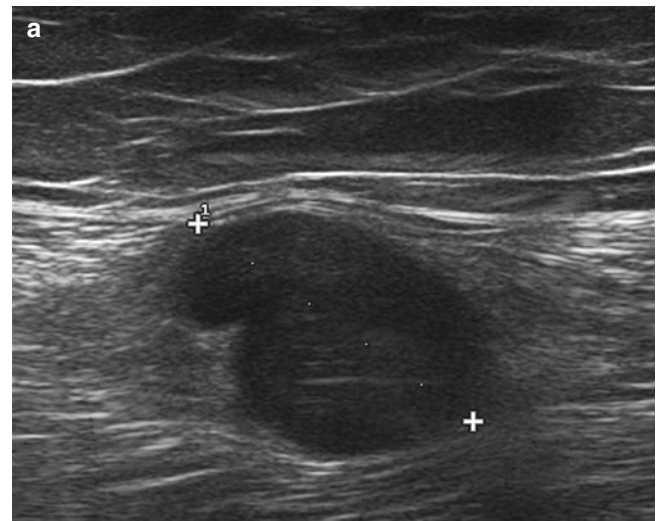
Presurgical guidewire. Ultrasound image (*a calipers*) shows a 24-mm intramuscular melanoma metastasis of the thigh. A wire (*b arrows*) is inserted into the large but deep lesion before surgery
